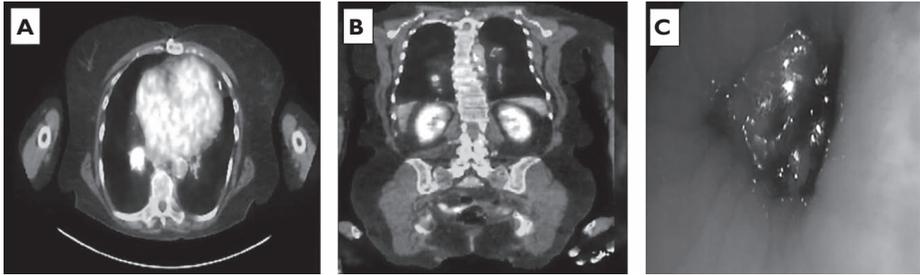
PET-CT scan showing hypermetabolic endobronchial lesion (A) and right upper lobe lung nodule (B). Bronchoscopy showed fungating endobronchial lesion with near total occlusion of the right lower lobe bronchus and the entrance of the right middle lobe bronchus (C).
